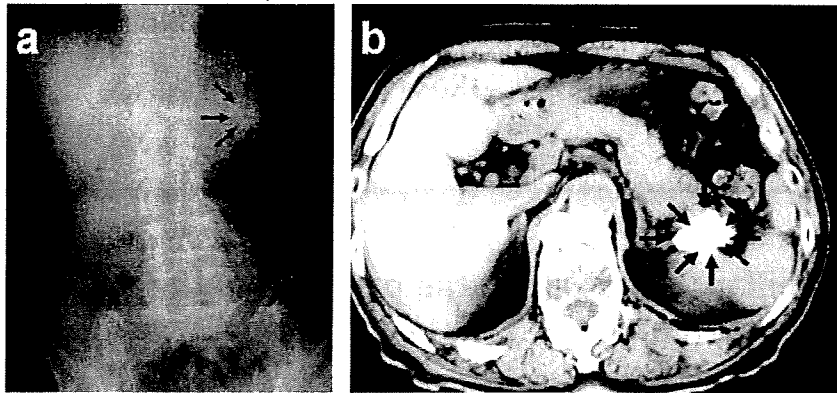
Preoperative abdominal X-ray film (a) shows a calcified shadow in the left subphrenic region, and preoperative abdominal computed tomography (b) reveals a calcified mass at the pancreatic tail (arrows).
